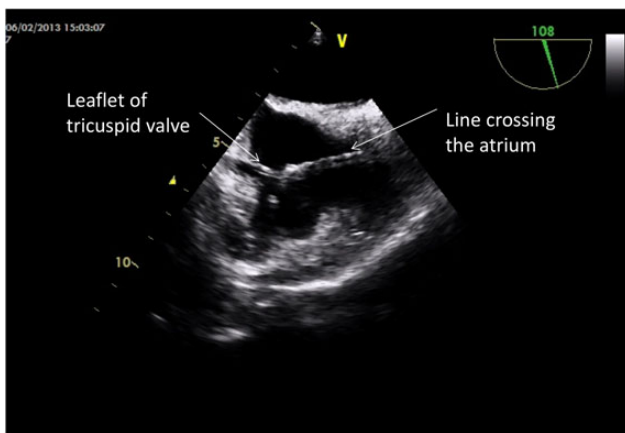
Trans-oesophageal echocardiogram with bicaval view showing the position of the line in relation to the tricuspid valve.
